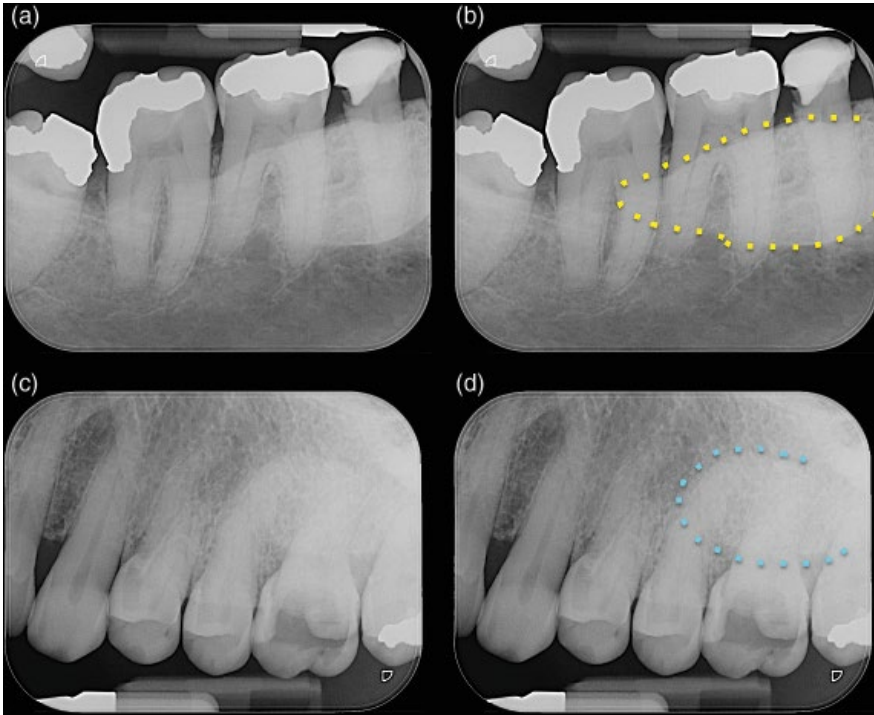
Tori. (a, b) Periapical radiographs of the mandibular right posterior teeth. A large mandibular torus can be seen as a well-defined radiopacity projecting over the roots of the 45 and 46 teeth (broken yellow line). (c–d) Periapical radiographs of the maxillary left posterior teeth. A large maxillary torus can be seen as less well defined radiopacity projecting over the roots of the 25 and 26 teeth (broken blue line).
